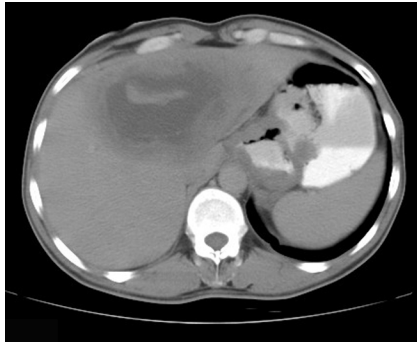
Contrast enhanced computed tomography (CECT) of the abdomen shows circumferential thickening of fundus, lesser curvature with irregular outer margins and multiple enlarged perigastric lymph nodes.
